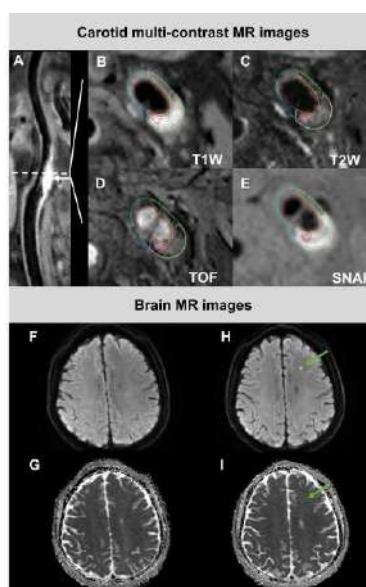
The images from a 56 years old male patients who had carotid plaque with Type-I IPH (pink), Type-II IPH (rose) and LRNC (yellow) in the left carotid artery (A-E), and silent stroke (green arrow) on DWI images following CEA (before CEA, F and G; after CEA, H and I).
